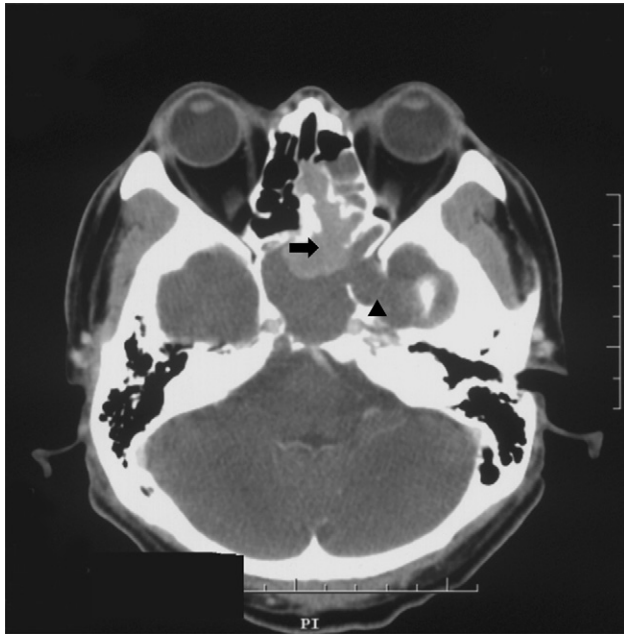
Computed tomography (horizontal) of the nasal cavity and paranasal sinus revealing a tumor mass (arrow) extending from the right ethmoid sinuses and involving the nasal cavity and sphenoid sinus. The sphenoid sinus is filled with fluid collection and there is a bone defect region (arrowhead) at the lateral wall of the sphenoid sinus.
